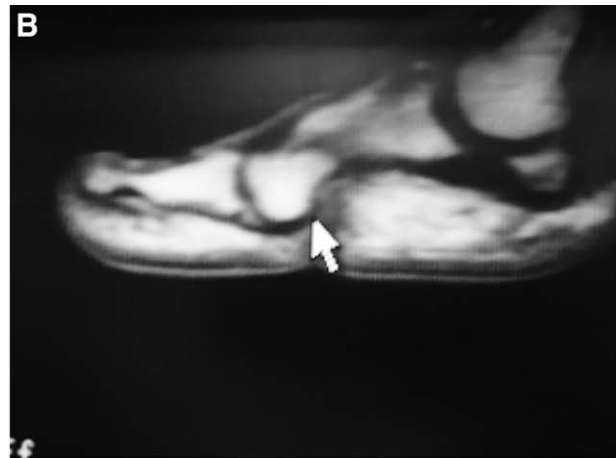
FHL tendon was not seen between the ankle and sesamoid bones in the frontal plane section (A) or the sagittal plane section (B) of the MRI of the patient's left foot.
